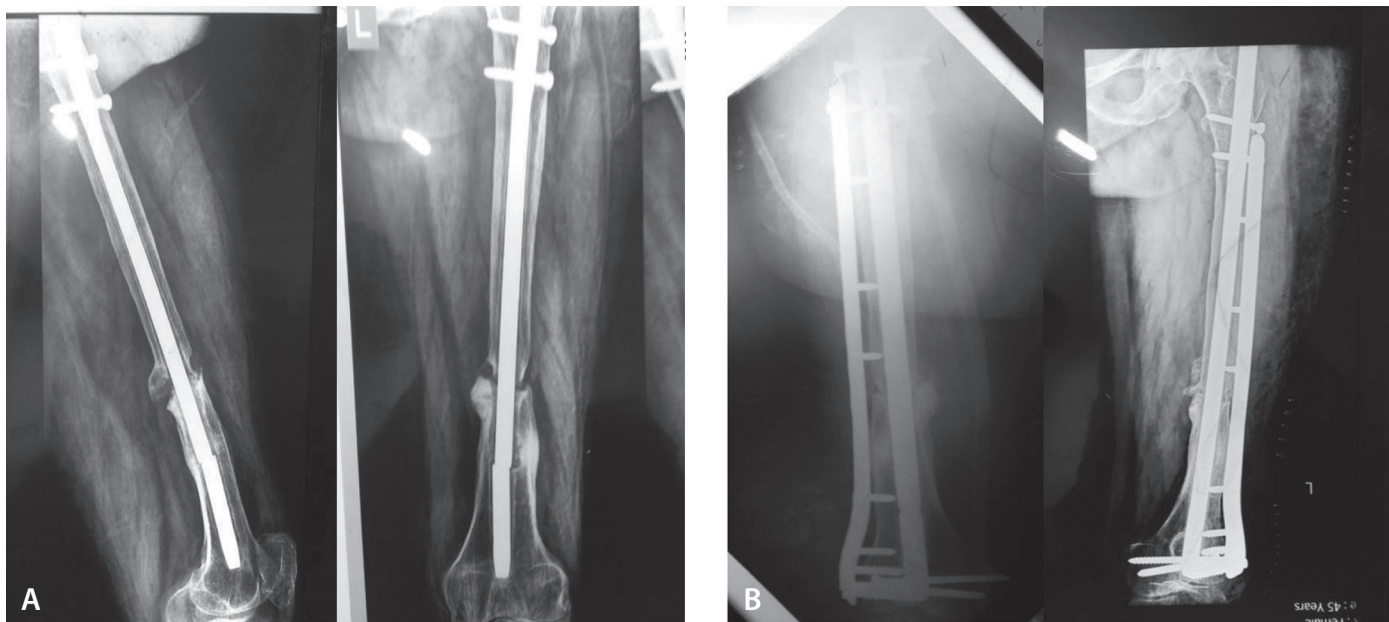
Fifty year old male with right distal one third femoral non-union. X-rays at (A) time of presentation and (B) 7 months postoperative.
